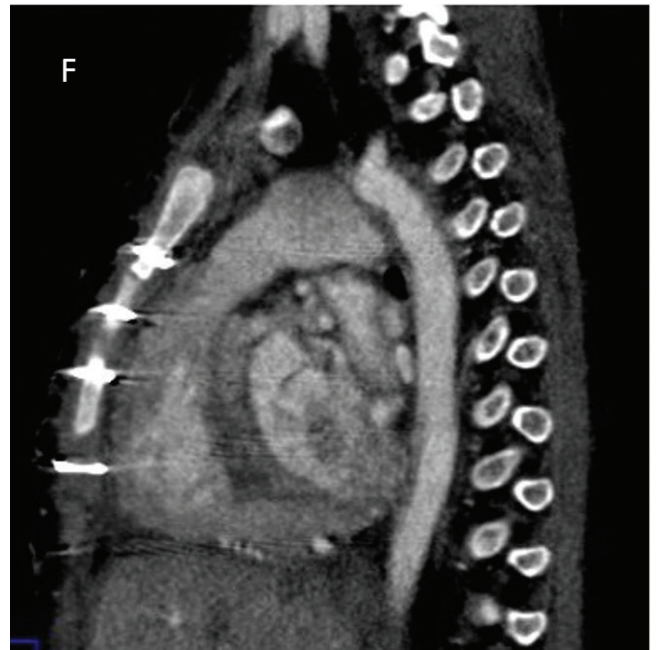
Postoperative CT (right ventricular outflow).
